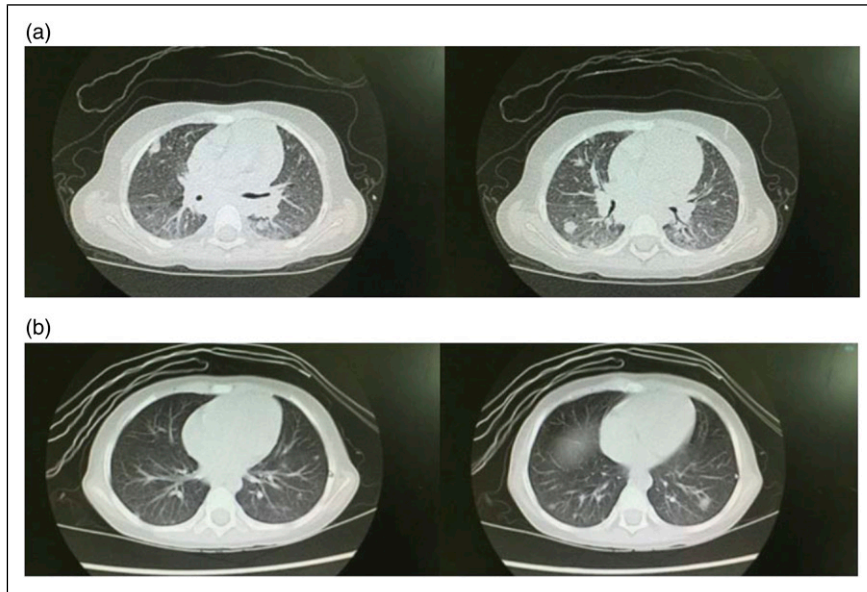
Comparison of lung CT before and after therapy: (a) Before and (b) after treatment.
